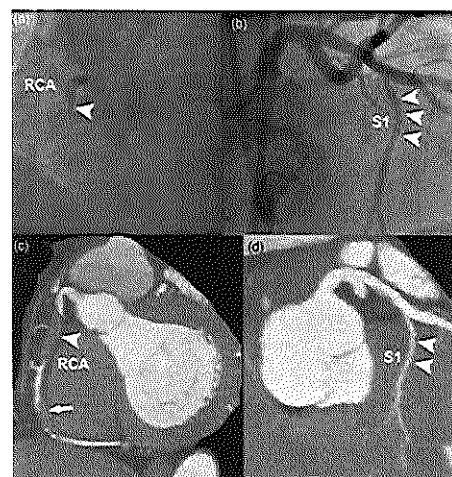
Retrograde approach. (a) Angiographic image, showing proximal occlusion (arrowhead) of the right coronary artery (RCA). (b) Angiographic image of the left coronary artery, showing a large septal branch (arrowheads). (c) Corresponding CT image of the RCA showing 2 consecutive non-calcified occlusions of the vessel. (d) Corresponding CT image of the left coronary artery, also showing the large septal branch.
